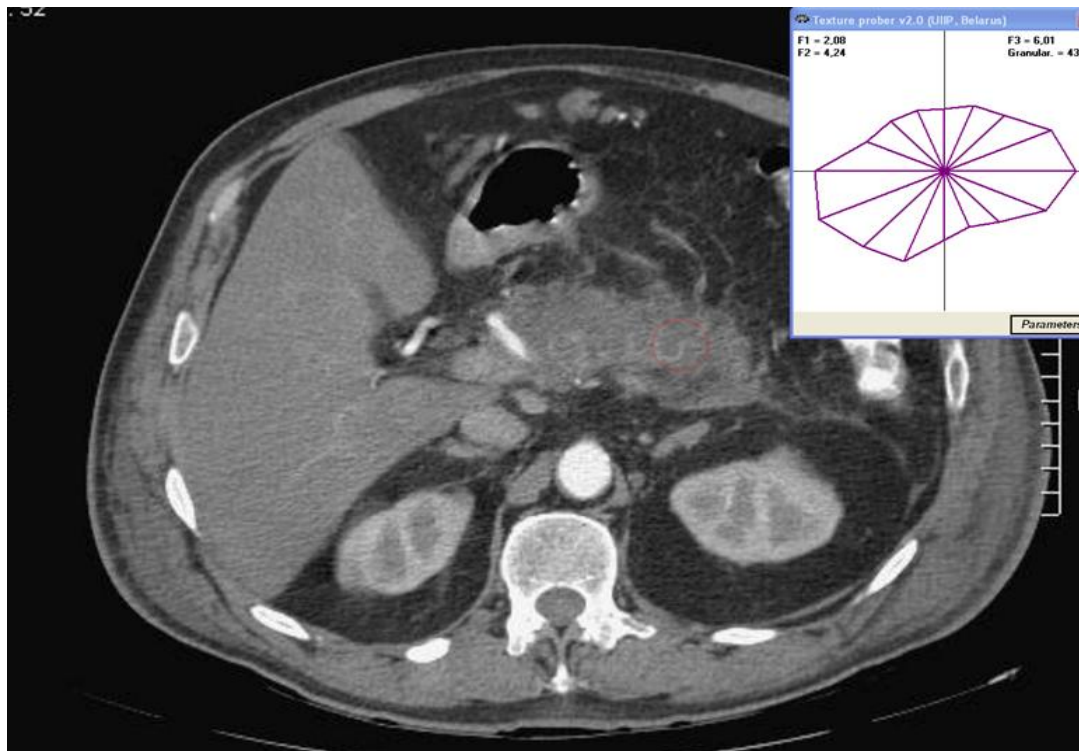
The method of analysis of CT images with the assessment of pancreatic tissue anisotropy; the cursor (circle) is induced in the region of interest, window in the upper right corner shows the anisotropy parameters.
